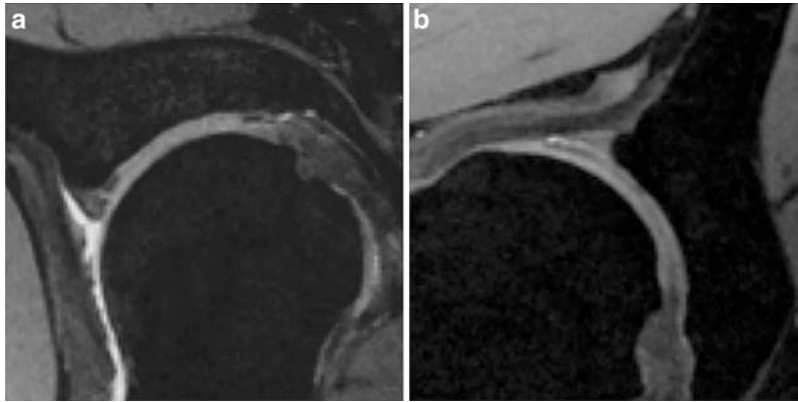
3D DESS MRI reformats demonstrating a radial (a) and a longitudinal (b) labral tear
